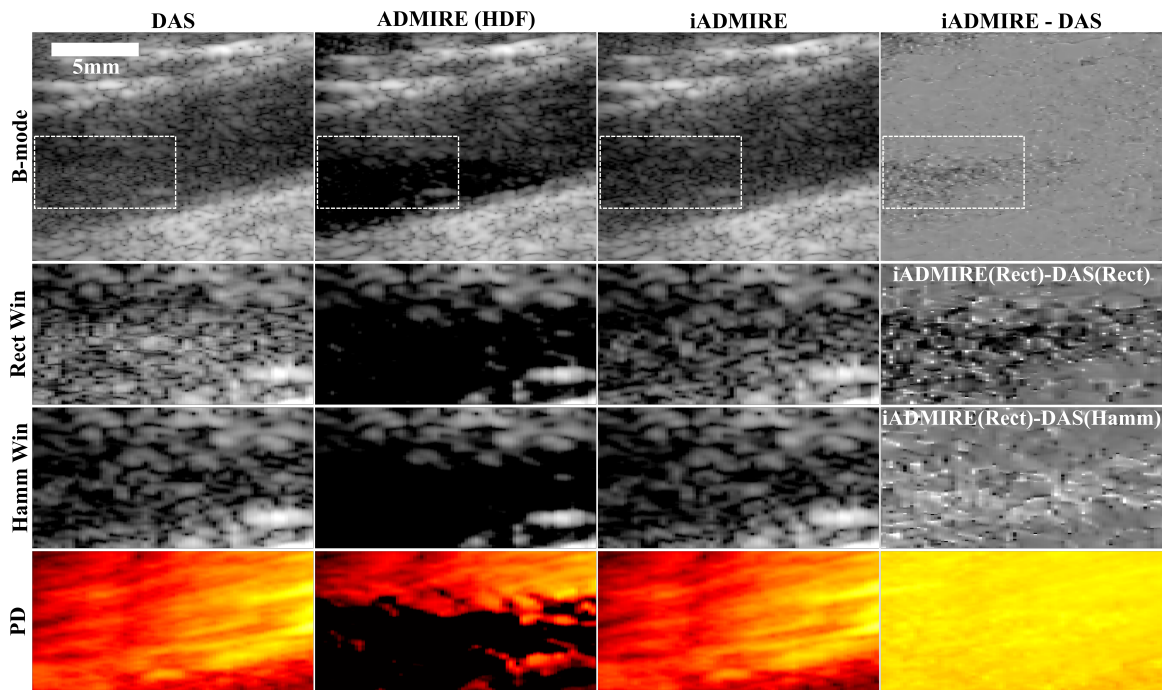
DAS, ADMIRE (HDF), iADMIRE, and the difference between iADMIRE and DAS images from an *in vivo* carotid artery from a healthy individual. The top row shows the standard B-mode images on a 70 dB log scale, and the middle and bottom rows show the dashed white line section from the B-mode enlarged. The middle rows show the same B-mode on a narrower 30 dB log scale using rectangular (Rect) and Hamming (Hamm) apodization, respectively, while the bottom row shows the power Doppler (PD) images on a 25 dB log scale. The lower dynamic range helps to highlight the improved speckle texture in the iADMIRE B-mode image. Figure ©2021 IEEE.
